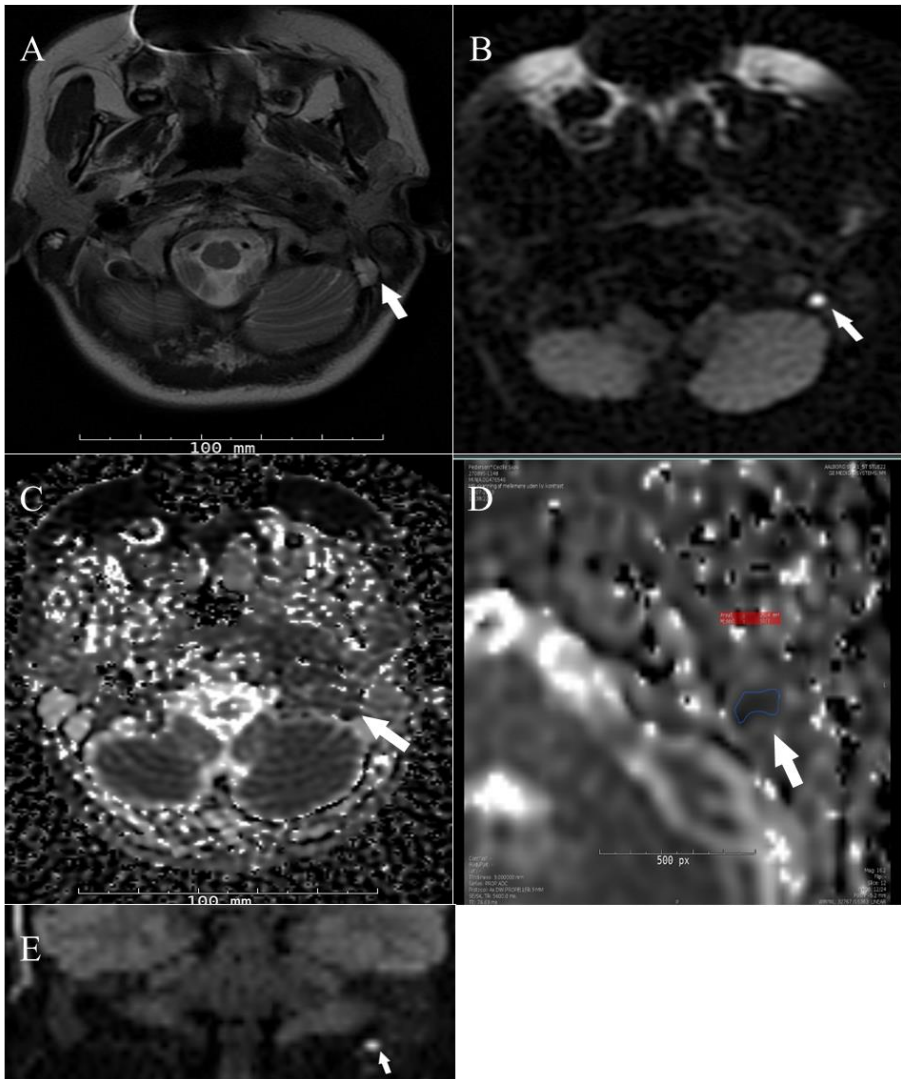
True Positive Cholesteatoma: MRI scans effectively pinpoint the cholesteatoma, validated by surgical outcomes. A patient diagnosed with a left ME cholesteatoma. The images display a recurrent cholesteatoma in the epitympanum, measuring 4 mm. In all images, the cholesteatoma is indicated by a white arrow. a) axial T2 image reveals a focal lesion with non-uniform characteristics and indistinct borders presenting with a high signal; b) axial DWI PROPELLER image shows limited diffusion with a pronounced hyperintense signal in the epitympanum; c) low signals are observed in the ADC image; d) the ADC value of the lesion (thin blue line) is measured on the axial ADC map, resulting in a value of $0.4936 \times 10^{-3} \text{ mm}^2/\text{sec}$; e)
